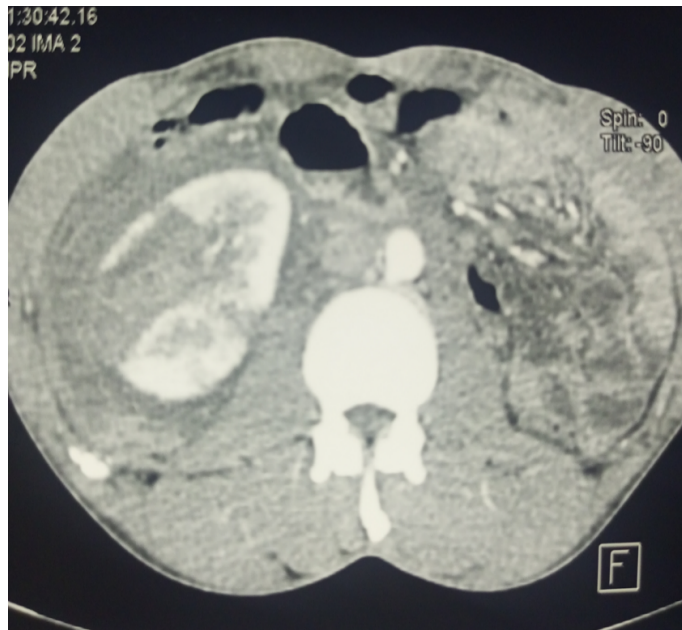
Contrast-enhanced CT urography (coronal view). Deep parenchymal laceration greater than 4 cm in the mid-inferior portion of the right kidney with subcapsular and perirenal hematoma; complete absence of the left renal parenchyma consistent with congenital left renal agenesis.
